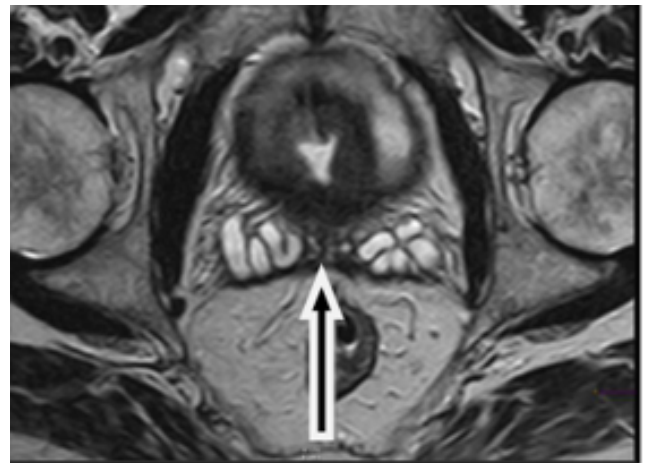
T 2 W axial-Appearance of seminal vesicle invasion on MRI
